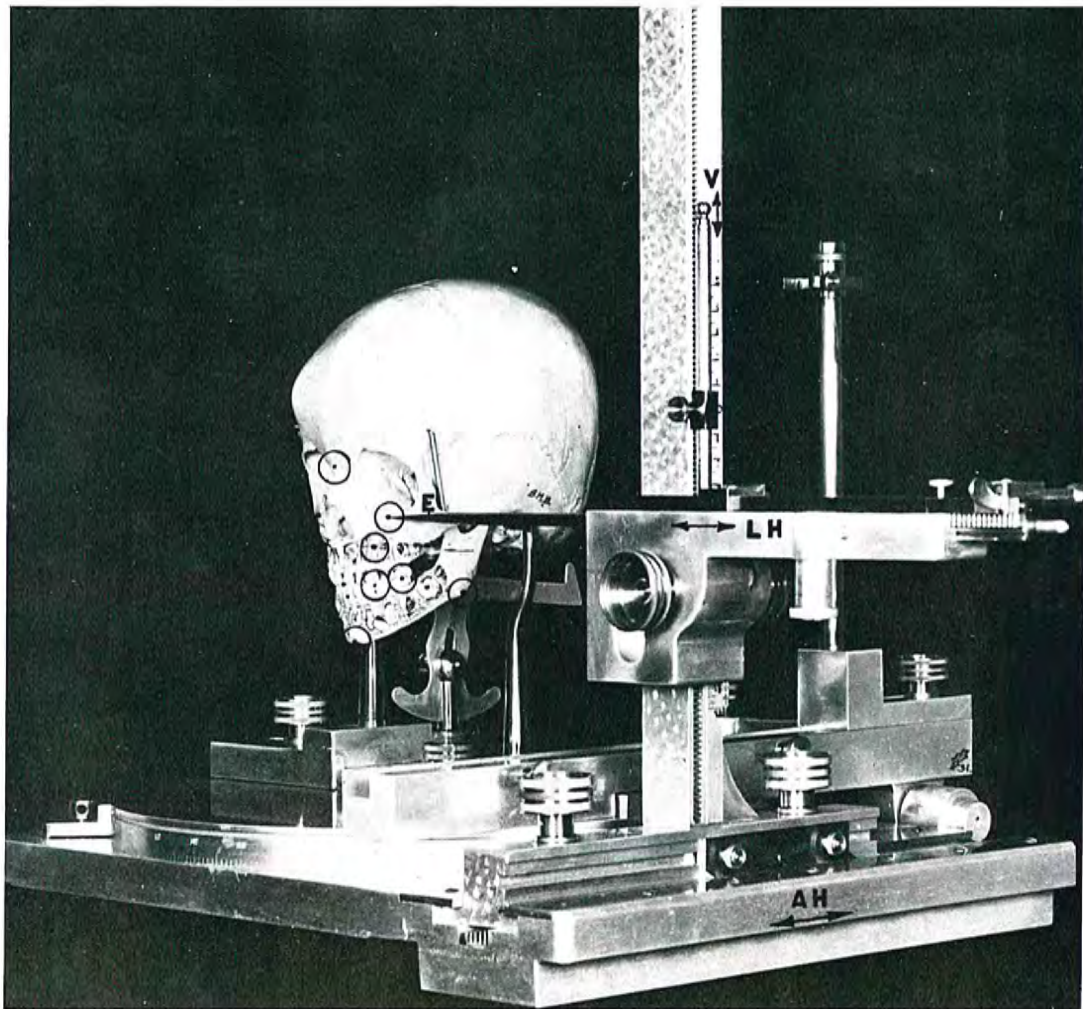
Radiographic craniometer, equipped with a channel for supporting a film cassette in precise relationship to the skull for taking standardized x-ray films.
